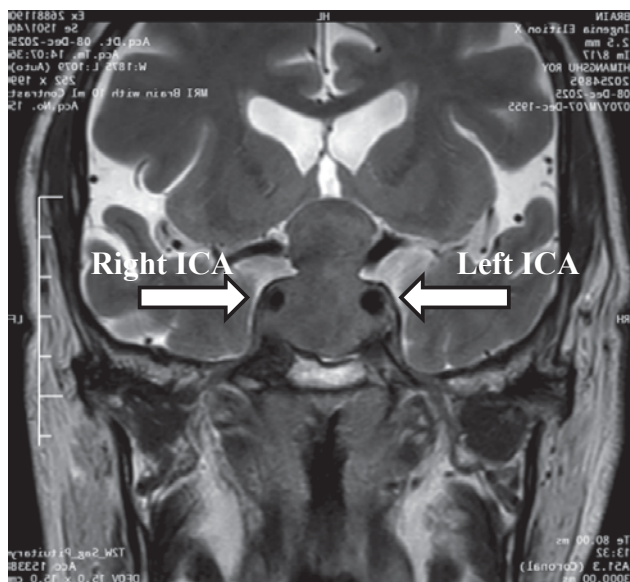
A ‘snowman’ shaped pituitary macroadenoma in sella with significant suprasellar extension, producing critical right cavernous carotid artery encasement shown in MRI of Brain.
